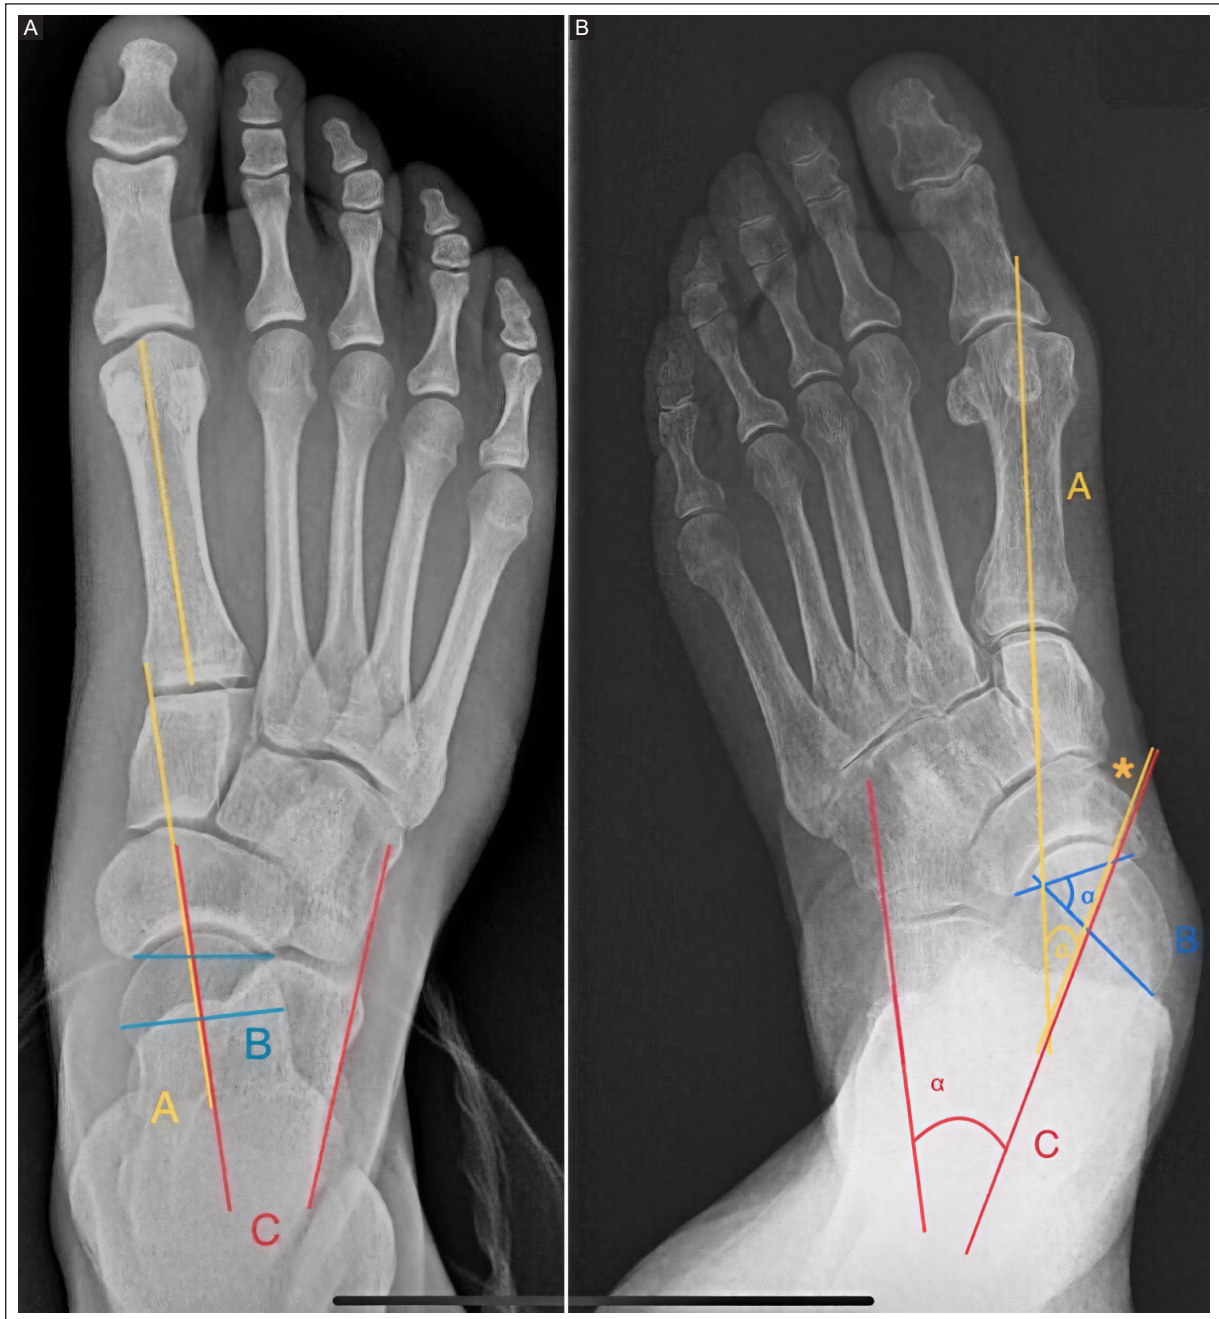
A: normal AP foot radiograph showing the talo-first metatarsal angle (yellow A), talonavicular coverage angle (blue B), and talocalcaneal angle (red C). B: same angles and color coding on an AP radiograph with deformity. The orange asterisk indicates insertional enthesopathy of the PTT as an indirect radiographic sign.
